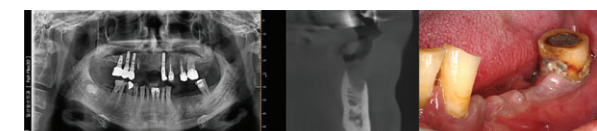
Pre-operative radiograph & Intra-operative view
